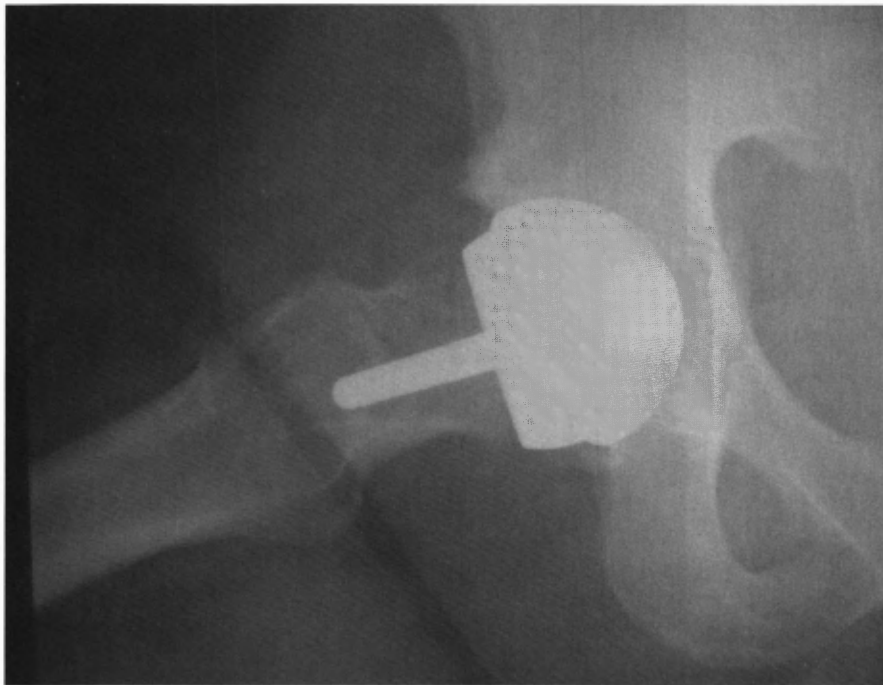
(A) Preoperative templating for THA. Stem and cup orientation and size are marked in addition to neck cut. Ideal cup position is 45 degrees abduction, and stems need to have equal leg lengths postoperatively. (B) Metal-on-metal postoperative radiographs revealing acceptable component position and leg lengths.
